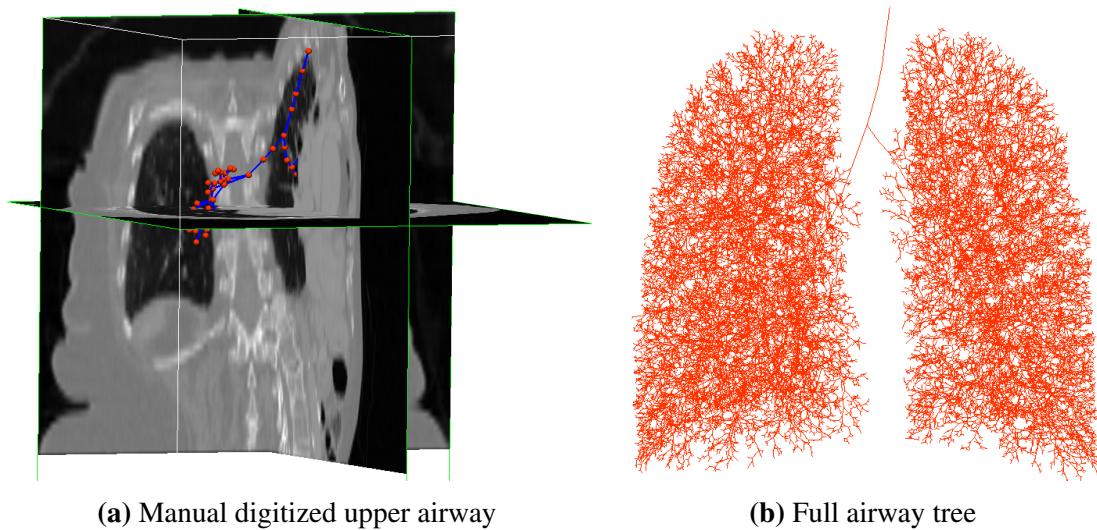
Generation of airway tree. (a) Manual digitized upper airway tree from HRCT images in 3D. Blue lines are the centerlines of upper airway tree, and red points represent airway nodes. (b) Geometry of full conducting airway tree generated using volume-filling algorithm. The model is shown from the anterior view, with the left lung on right, and right lung on left.
